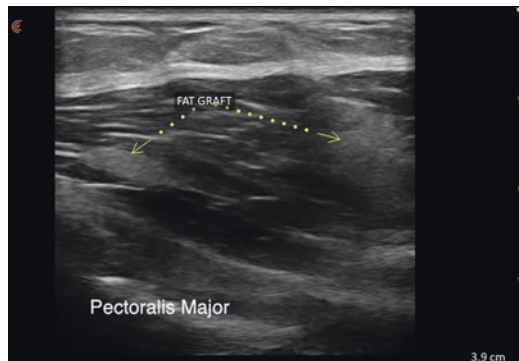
Grayscale ultrasound image of chest wall. Hyperechoic parcels of fat are seen the normal striations of the pectoralis major muscle
